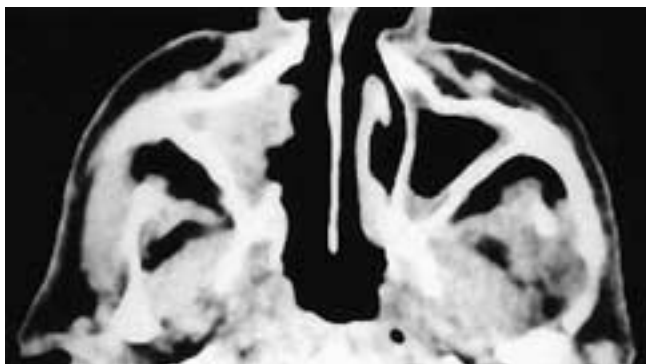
Axial CT scan on a patient after right medial maxillectomy. The soft tissues within the right sinus have a nodular contour and suggest recurrent tumor. Inflammatory disease is present in the left antrum. This patient had recurrent inverted papilloma.
